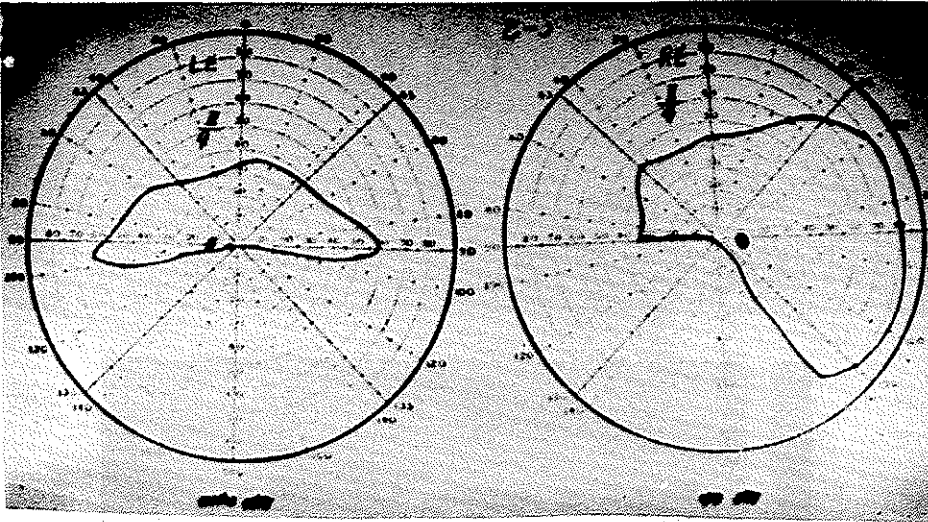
A-Visual fields showing an important defect at the inferior part of the left field and defect of the infero-nasal sector of the right. B-CT Scan showing occipital lobes lesions (arrows).
